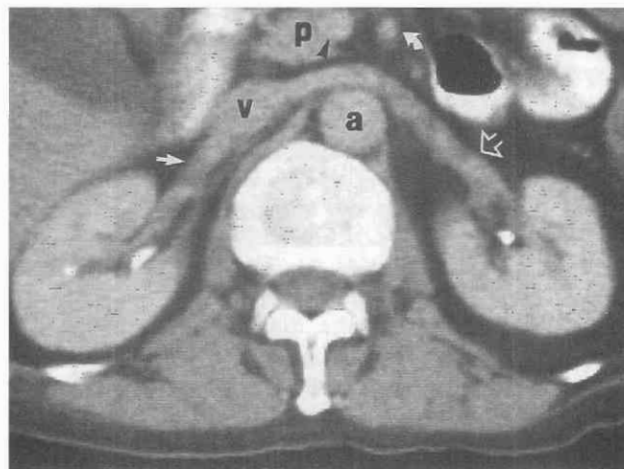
Normal CT renal anatomy. The longer left renal vein (open arrow) passes between the aorta (a) posteriorly and the superior mesenteric artery (curved arrow) anteriorly. It joins the inferior vena cava (v) at the level of the uncinate process of the pancreas (p). The right renal vein (arrow) is shorter.
